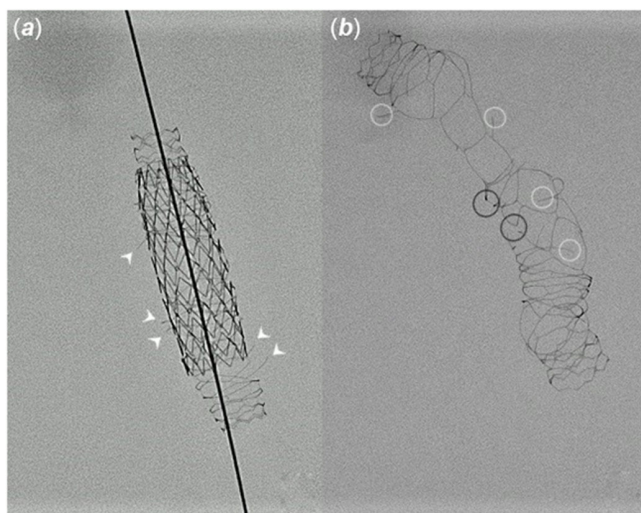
Anteroposterior X-ray acquisitions shots of the BeSmooth $\varnothing 10 \times 23$ mm after inflation of 48 mm-long Optimus XXL stent and balloon rupture. Note the multiple and dispatched strut fractures with inward and outward orientations (white pointed arrows) (a). Same BeSmooth $\varnothing 10 \times 23$ mm re-inspected after carefully taking out Optimus stent. Note the total stent distortion with radial (connection between cells) (black circles) and longitudinal (within the cell line) (white circles) fracture lines (b).
